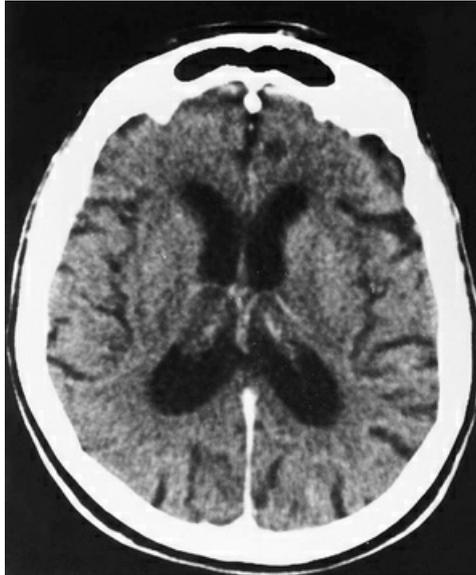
Alzheimer's disease. Noncontrast CT scan of a 56-year-old woman with progressive dementia shows generalized enlargement of ventricular system and sulci. (From Eisenberg RL: *Comprehensive radiographic pathology*, ed 6, St. Louis, 2016, Elsevier.)
